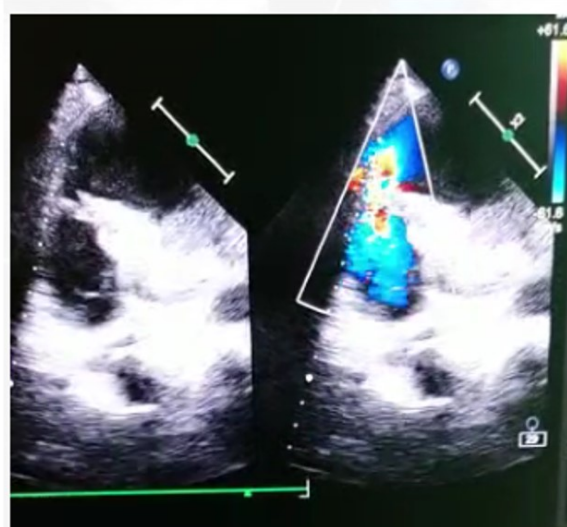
Echocardiogram shows ventricular septal rupture with left to right shunt
